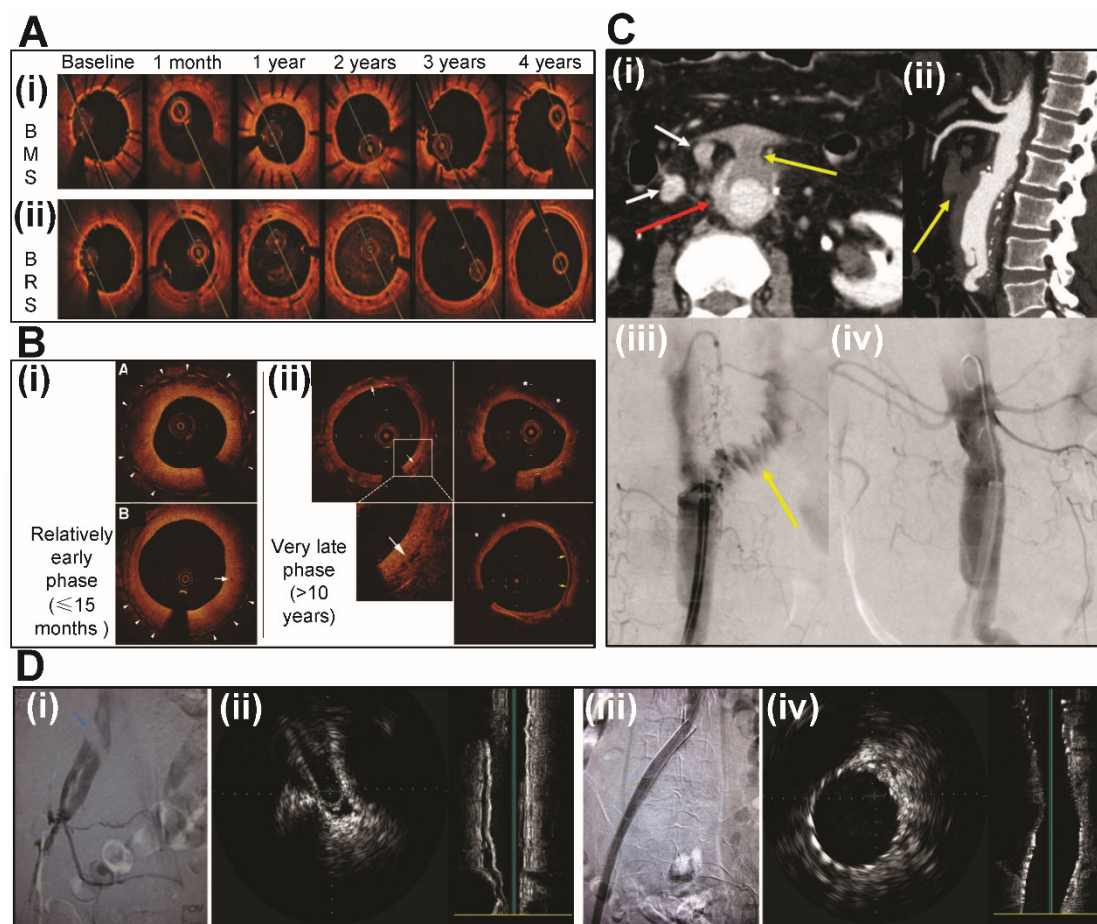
Potential clinical applications and imaging evaluation of vascular stents in different vascular beds. (A) Coronary artery atherosclerosis: Serial optical coherence tomography (OCT) over 4 years comparing (i) BMS and (ii) BRS. BMS maintain stable lumens; BRS enlarge (2–4 years) via remodeling and plaque regression [214]. (B) Peripheral artery atherosclerosis: OCT of BMS responses at (i) Relatively early (≤ 15 months) and (ii) very late (>10 years) phases. Relatively early phase shows peri-strut low-intensity areas (PLIA, arrowheads) and microvessels; very late phase shows neoatherosclerosis with lipid-rich intima (asterisks) and calcium (yellow arrows) [215]. (C) Aortic atherosclerosis: Computed tomography angiography (CTA) (i, ii) and digital subtraction angiography (DSA) (iii, iv). (i) Axial CTA shows infected anastomotic pseudoaneurysm (red arrow), partially thrombosed aorto-duodenal fistula (yellow arrow), and periaortic lymphadenopathy (white arrows). (ii) Sagittal CTA shows fistula extent (yellow arrow). (iii) Pre-interventional DSA confirms duodenal contrast extravasation (yellow arrow). (iv) Post-interventional DSA shows fistula sealed by endoprosthesis [216]. (D) Other vascular diseases (May-Thurner syndrome): Venography and intravascular ultrasound (IVUS). (i) Pre-interventional venography shows left common iliac vein compression by the right common iliac artery with collaterals. (ii) Pre-interventional IVUS confirms narrowed lumen. (iii) Post-interventional venography shows patent inferior vena cava flow. (iv) Post-interventional IVUS verifies optimal stent expansion, wall apposition, and venous caliber [217].
